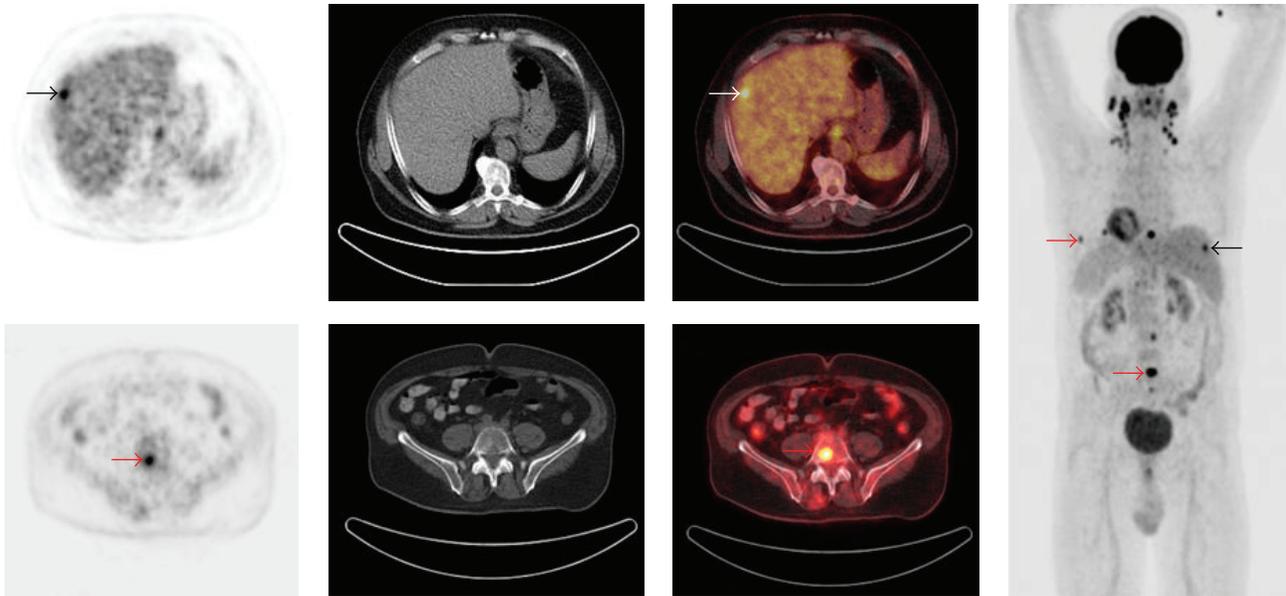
A 61-year-old man with nasopharyngeal SCC and bilateral cervical lymph node metastases underwent PET/CT for staging. Axial PET, CT, PET/CT, and maximum intensity projection (MIP) images are shown. PET/CT revealed focal FDG uptake in the right liver lobe indicating liver metastasis (black, white arrows). PET/CT also revealed multiple focal FDG uptakes in the lumbar spine, sternum, and ribs indicating multiple bone metastases (red arrows). PET/CT was valuable for detection distant metastases.
